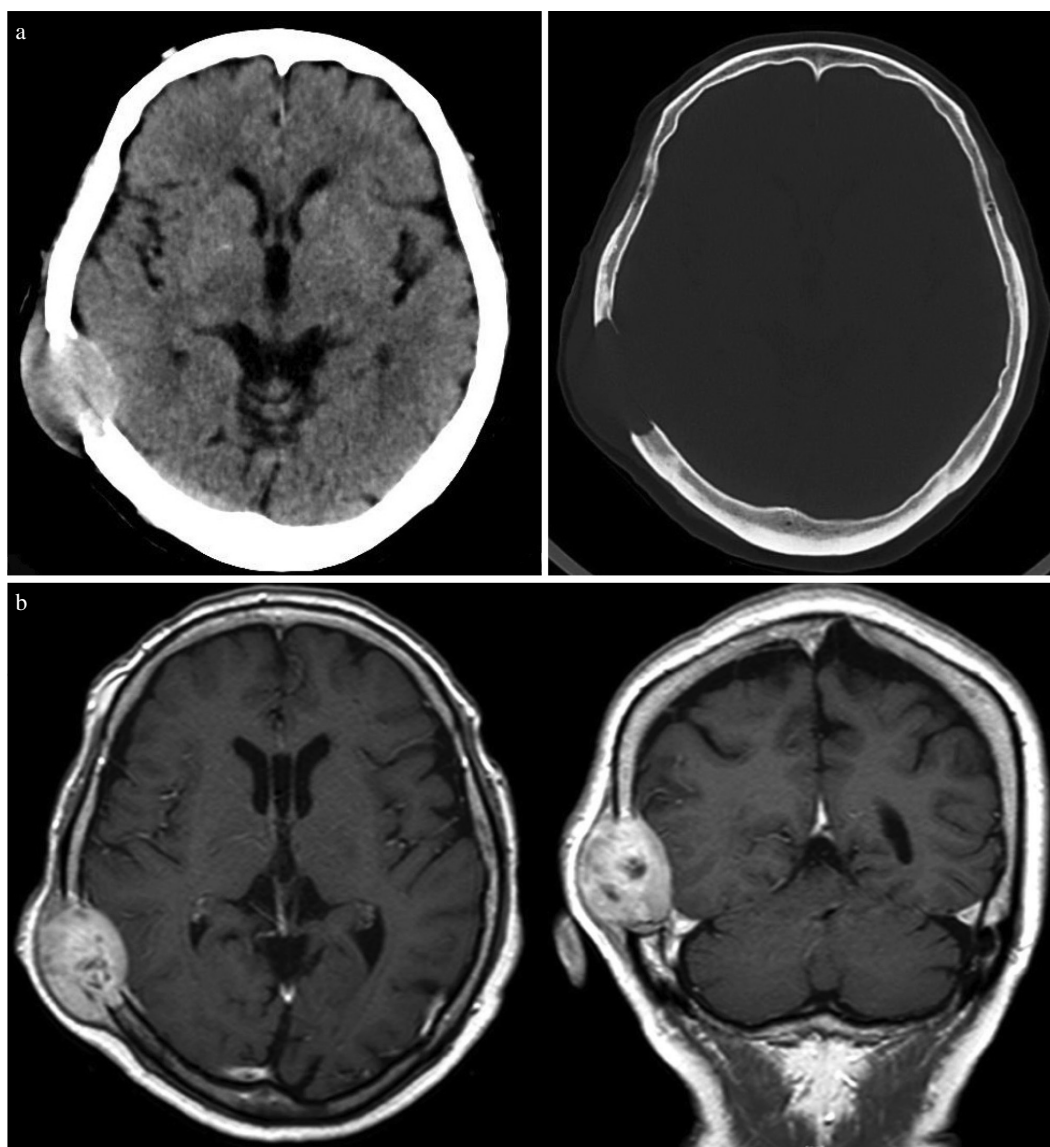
(a) Head CT scan shows a hyperdense lesion in the right parietal area. CT scan with bone window shows remarkable bone destruction of the right parietal skull. (b) Gd-enhanced MRI shows a heterogeneously enhanced lesion, adjacent to the mastoid air cell.
